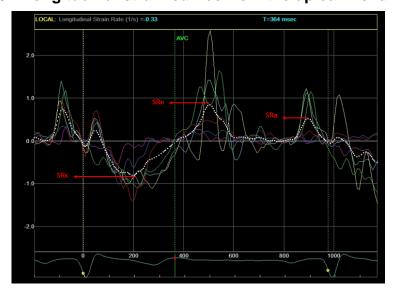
7 Longitudinal SR curves from the apical 4-chamber view. SRs = systolic SR, SRe = early diastolic SR, SRa = late diastolic SR.
